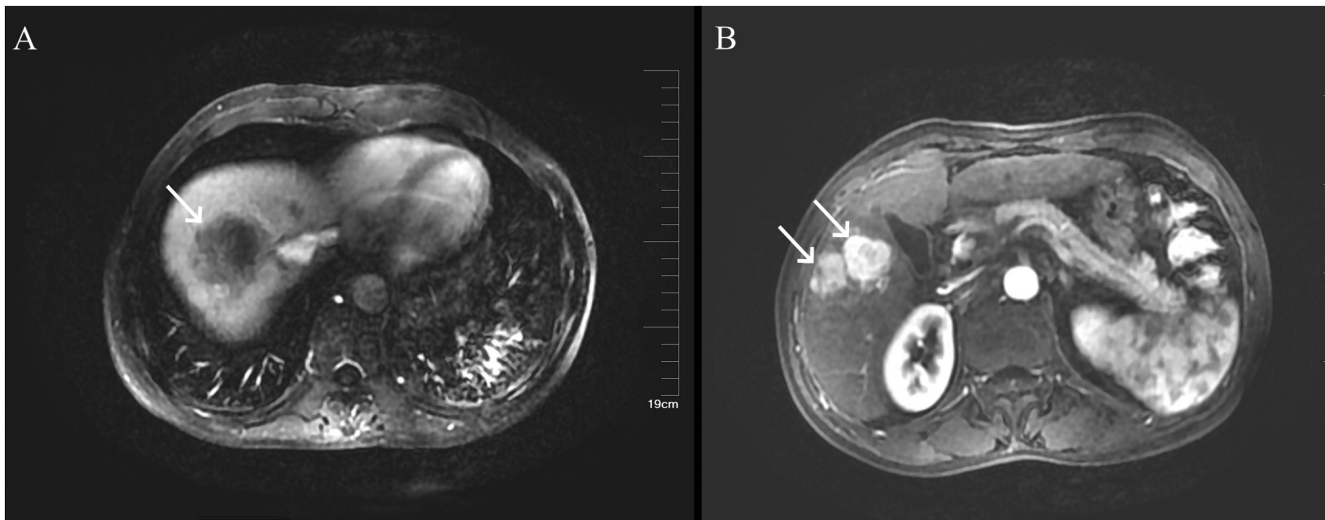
Case 2: Enhanced MRI of the liver. (A) A roundish mass (indicated by the white arrow) was identified in segments VII and VIII of the liver, measuring $\sim 4.9 \times 4.6 \times 3.6$ cm. (B) Multiple round-like masses were detected within the liver. The largest one (indicated by the white arrow), measuring ~ 2.7 cm in diameter, was located in segment V.
